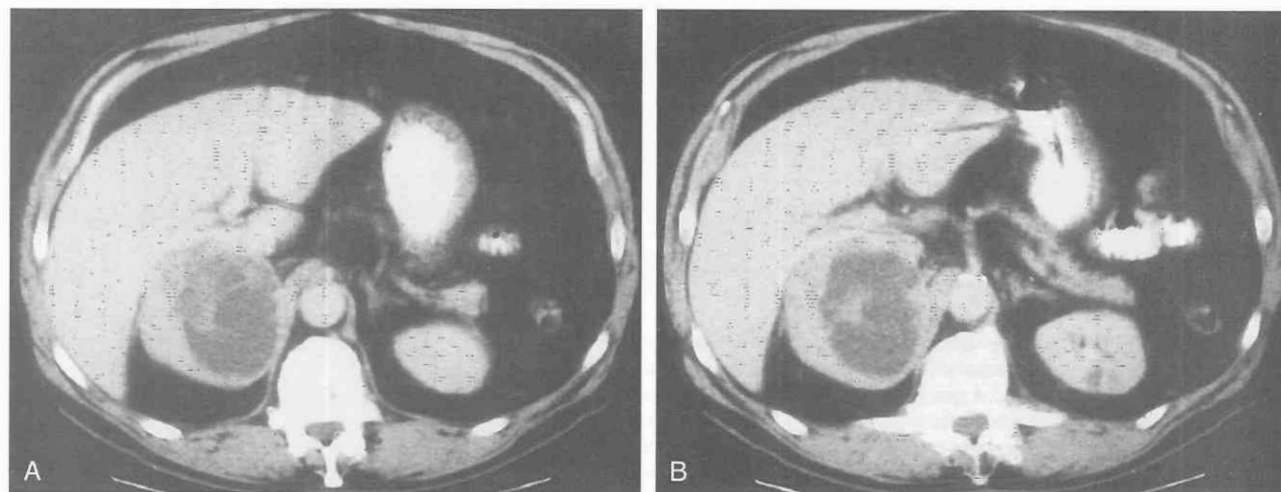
Pheochromocytoma. A and B, Contrast-enhanced CT scans of the abdomen demonstrate a 6-cm cystic right adrenal pheochromocytoma. (Courtesy of Mayo Foundation.)
